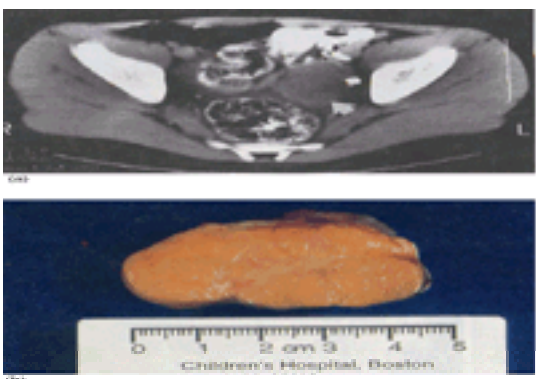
An ultrasound obtained on an 8-year-old girl who presented with a 1-year history of abdominal pain demonstrated a left adnexal mass. (a) The CT scan demonstrated a homogeneous mass (arrow). (b) Cross-section of the ovarian mass demonstrated the characteristic lobulated pattern without necrosis of a dysgerminoma.
